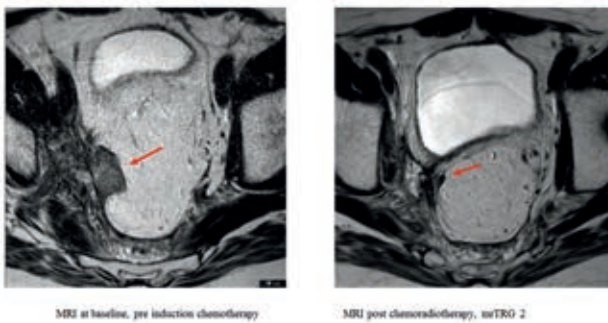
MRI at baseline and post chemoradiotherapy showing a near complete radiological response (i.e. mrTRG 2). In this case, restaging was performed < 7 weeks
